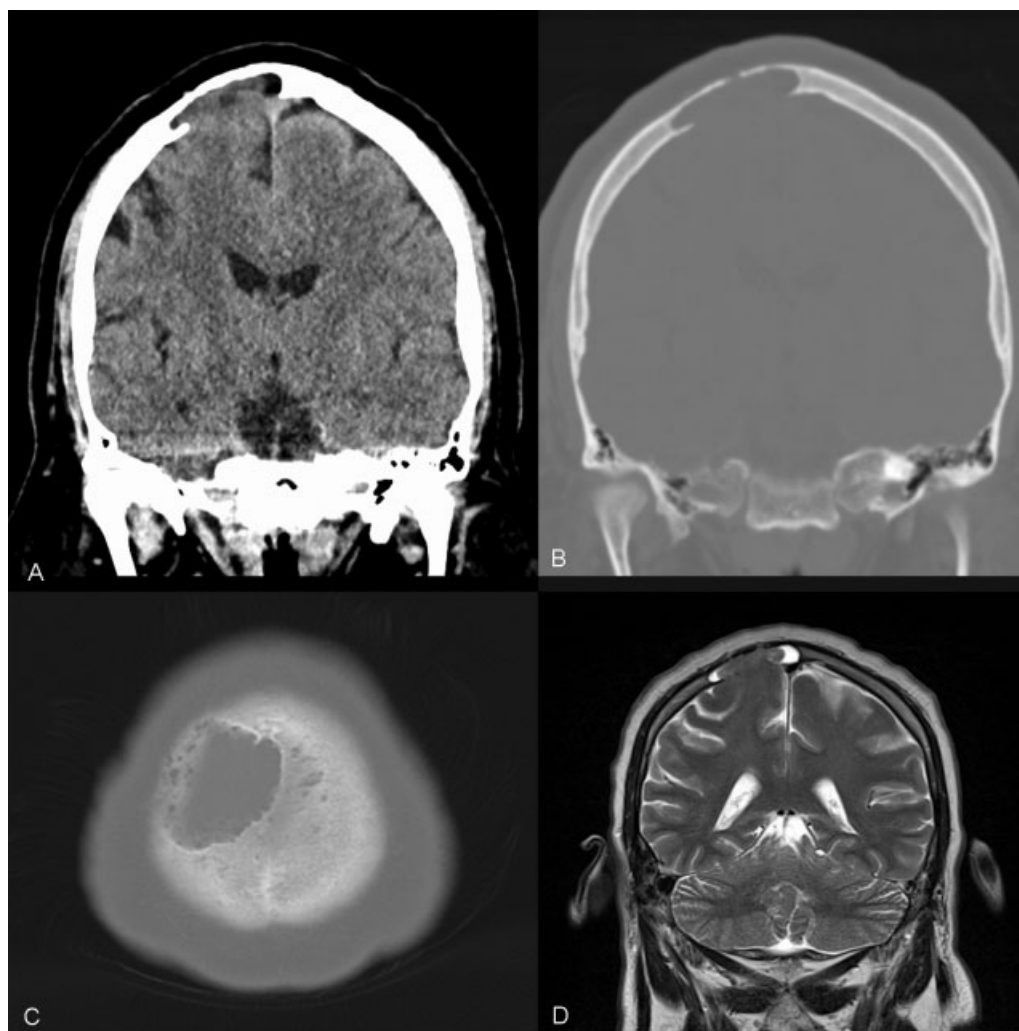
A 3-mm (A, B) coronal and (C) axial reformats in both (A) brain and (B) bone windows on (D) CT and coronal MRI showing herniated brain parenchyma. CT, computed tomography; MRI, magnetic resonance imaging.
